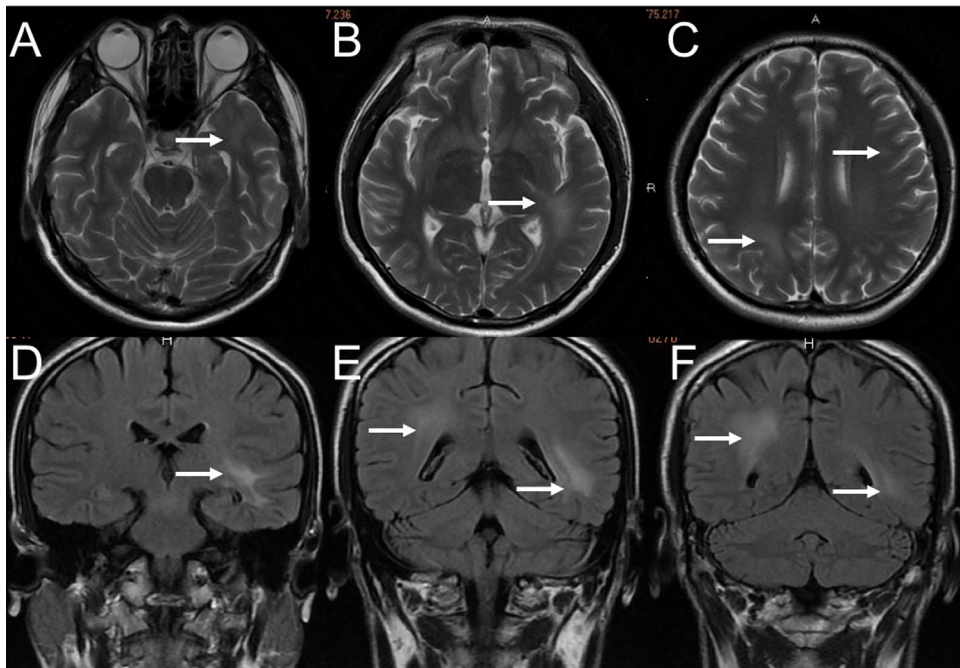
Brain MRI in March 2015. Brain MRI showing multiple hyperintense T₂ lesions and T₂ FLAIR lesions within the left temporal pole (A) and right parietal-occipital lobe (C, E, F), left temporal lobe (B, D), left inferior horn of the lateral ventricle (B, E, F), and left frontal lobe (C).
